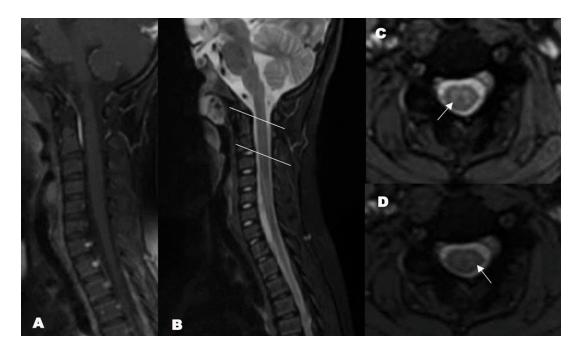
Cervical spinal cord MRI at 6-month follow-up: Sagittal section T1-weighted spin-echo sequence after gadolinium injection (A) and in T2-STIR sequence (B). Axial sections (C and D), T2-STIR sequence. There was a considerable decline in the signal intensity from the spinal cord lesion with no enhancement detected.
